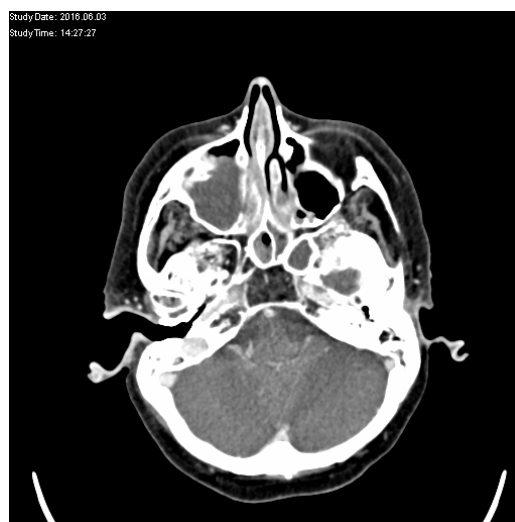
CT-Head 3.6.2016
